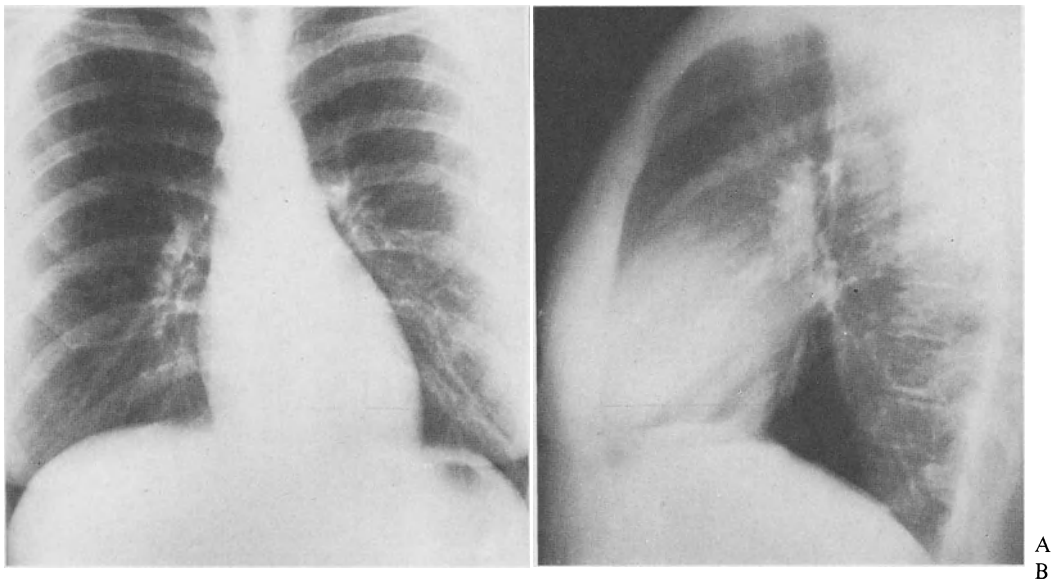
Conventional chest X-rays taken in the posteroanterior (A) and left lateral (B) position. This 24-year-old female complaining of intermittent extrasystolic heart beats was judged to have a heart of normal size. Cardiac catheterization revealed an early COCM (compare with Fig. 2B)
